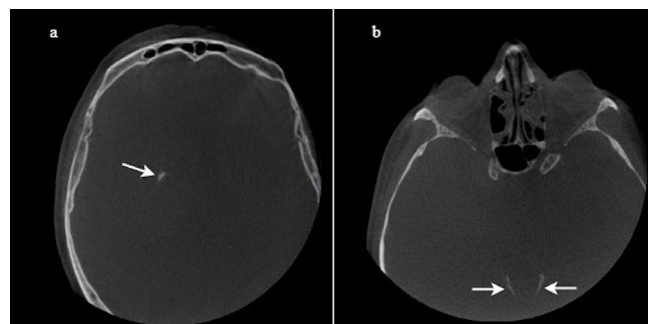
Axial CBCT images indicate (a) basal ganglia calcification (arrow), (b) tentorium cerebelli calcification (arrows).
